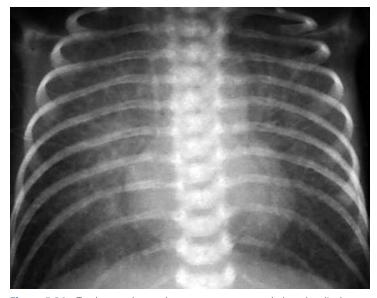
Total anomalous pulmonary venous return below the diaphragm. Note the radiographic findings of severe pulmonary venous obstruction and pulmonary edema, mimicking respiratory distress syndrome or some other primary pulmonary pathology.
